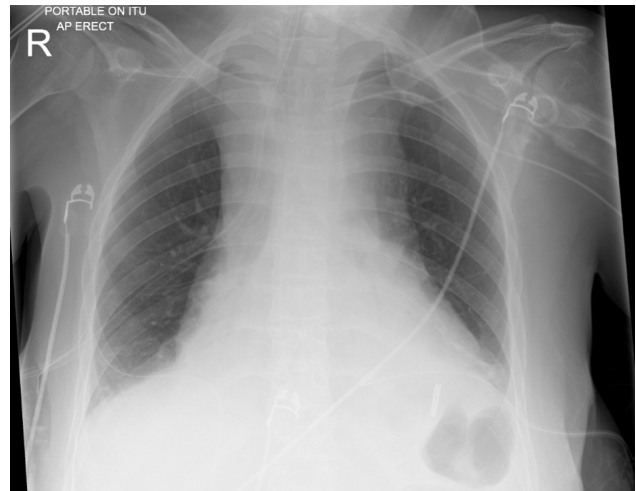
Chest X-ray post BL chest drain insertion
